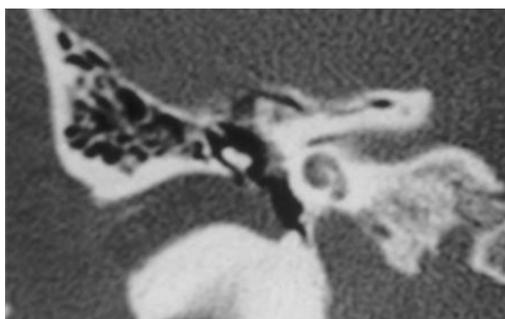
Coronal cut CT scan of the right temporal showed a mass in the external auditory canal, although examination using a bone window setting, the presence of a low density indicated fat direction
